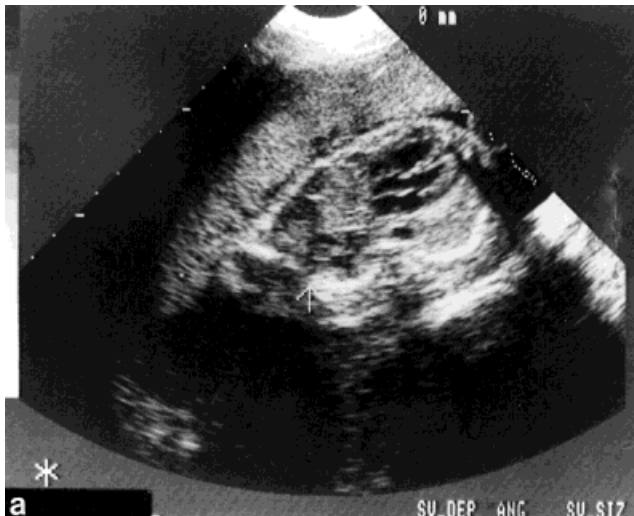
Patient 2. a: Level II fetal sonogram at 28 weeks of gestation, showing right multicystic CCAML (arrow), measuring 2.8×2.3 cm; at 33 and 36 weeks the CCAML showed a regression in size, to $2.6 \times 2 \times 2$ cm and $1.4 \times 0.8 \times 0.5$ cm, respectively. b: Chest radiogram at birth. No evidence of CCAML.
